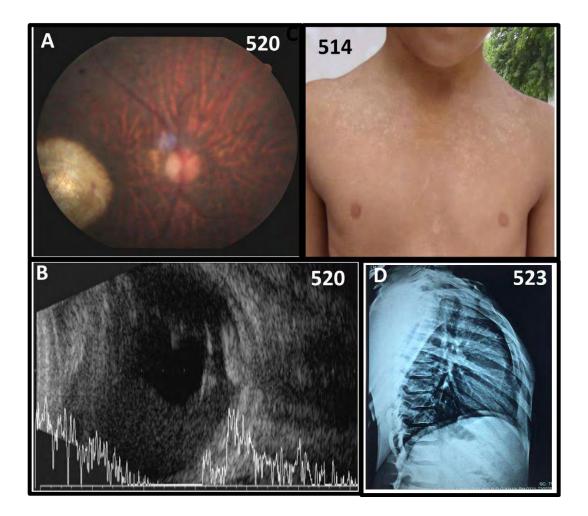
Clinical and morphological features of affected subjects 520, 514, and 523.A: fundus photograph of left eye, B: ultrasound (Beta-scan) of right eye; C: hypopigmentation; and D: roentgenogram of chest
